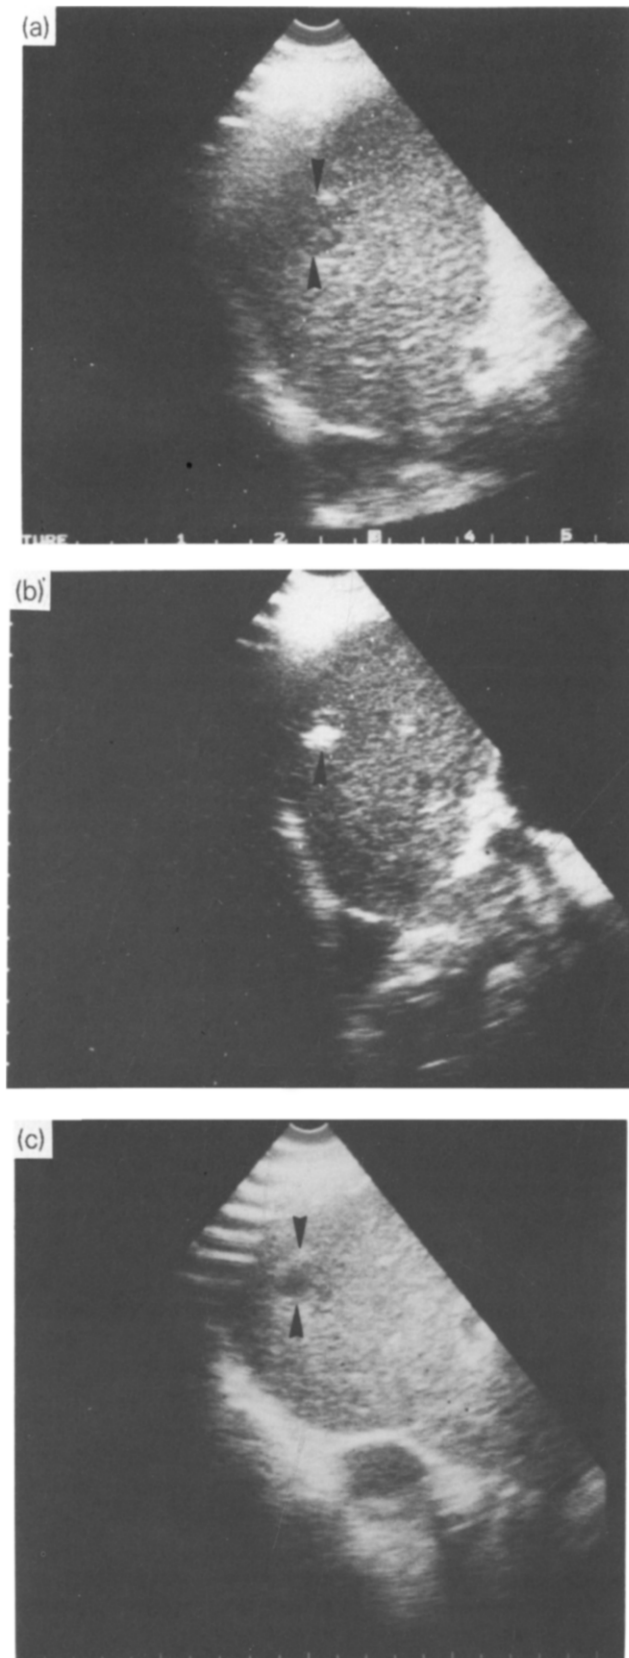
The sonographic pictures before and after laserthermia of case 3. (a) A small hypoechoic tumour was detected by ultrasound (arrowheads). (b) Immediately after laserthermia, a hyperechoic area was seen (arrowheads). (c) 4 months later, the tumour was more hypoechoic, and partly anechoic (arrowheads).
